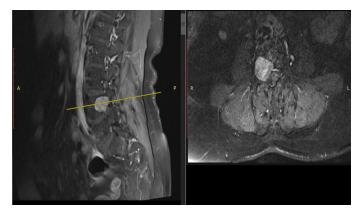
A 70-year-old female patient who experienced low back and right leg pain for 5 months. C+T1WIs revealed a well-circumscribed lesion that eroded the right pedicle of the L4 vertebra and measured 27×28×16 mm, narrowed right L4 foramen and heterogeneous enhancement after contrast. She underwent an operation and neurosurgeons identified the lesion to be intradural extramedullary intraoperatively. GTR was performed. The lesion was confirmed to be a schwannoma. The patient's pain was relieved, and she was intact neurologically on her fifth-year postoperative control visit. Left side: sagittal C+T1WI; right side: axial C+T1WI GTR: Gross-total resection, MRI: Magnetic resonance imaging, WHO: World Health Organisation
